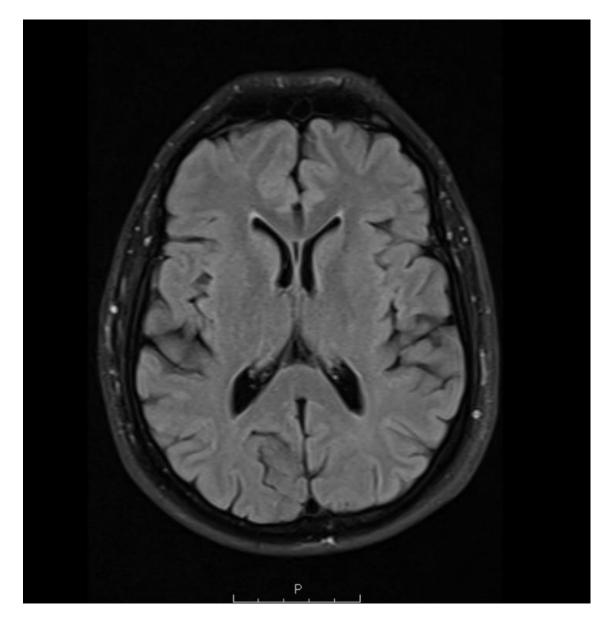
Normal axial T2-weighted dark fluid MRI image of the brain of the patient.
